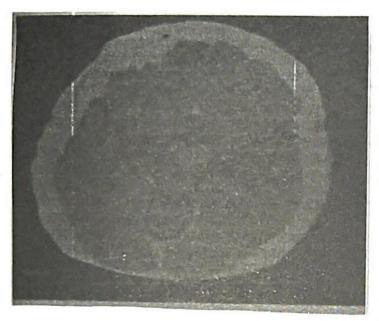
Brain CT scan with contrast showing ring enhancement of the multiple tuberculomas
